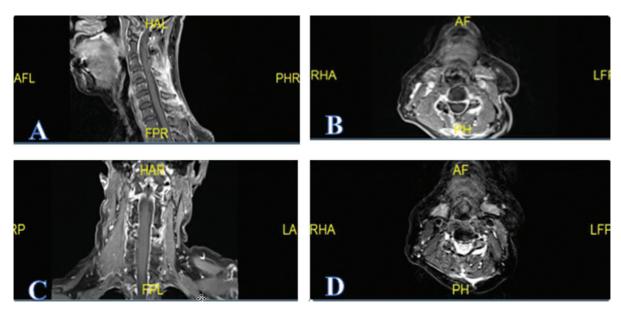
(A) Sagittal T1-weighted (T1W) post-contrast, (B) axial T1W post-contrast, (C) coronal T1W post-contrast, (D) axial T2W follow-up magnetic resonance image post-specific treatment with Staphylococcus aureus showing a good response with no sign of recurrence.
